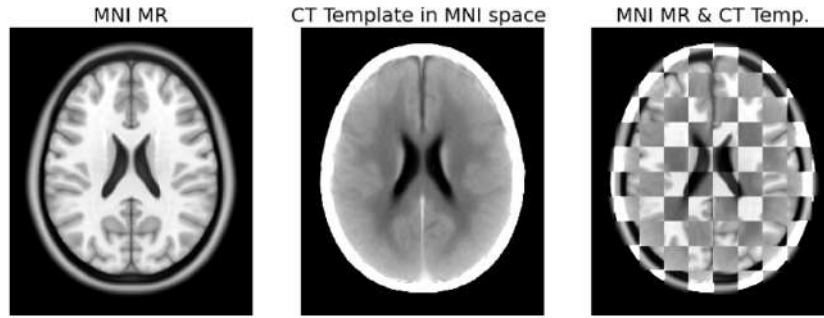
Final qualitative registration result, further referred as CT-MNI template. Registration of the study-specific CT template to the MRI MNI atlas.
